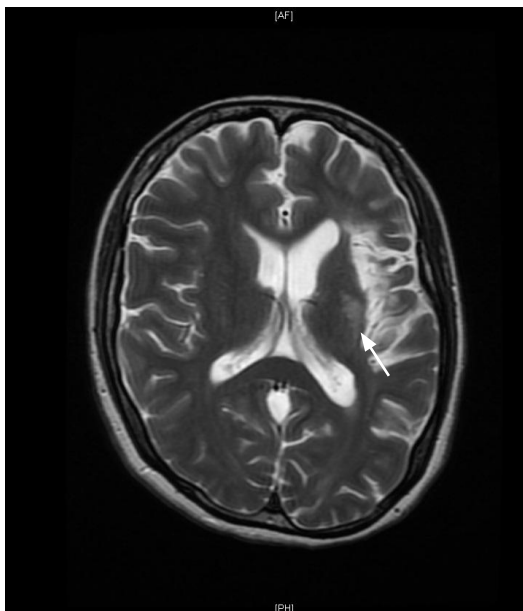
Magnetic resonance imaging T2 sequence showing old infarct in the left fronto-temporal lobe and insular region (arrow)
